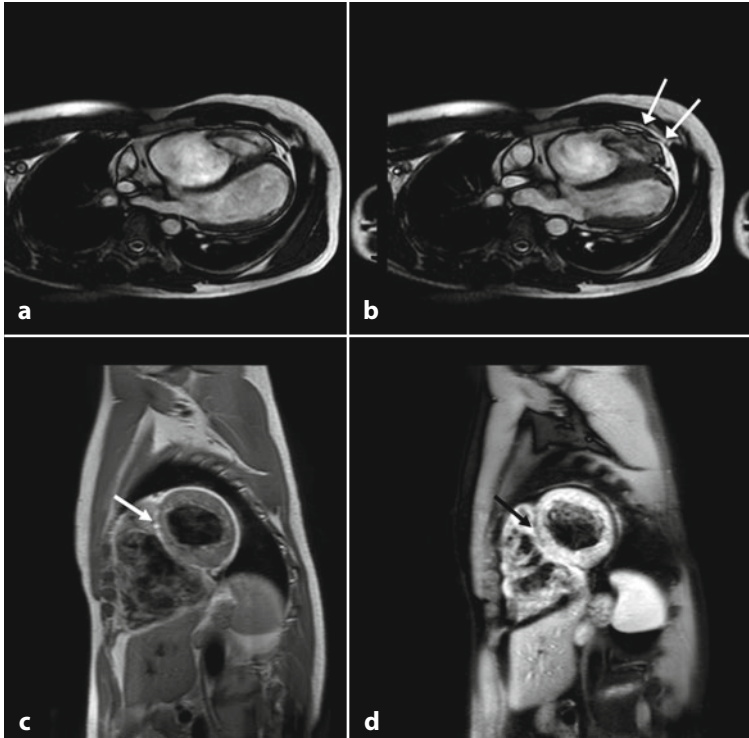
Magnetic resonance images of arrhythmogenic right ventricular cardiomyopathy in a 40-year-old patient. End-diastolic (a) and systolic (b) still-frames obtained from four-chamber stack steady-state free precession cine-imaging, showing systolic bulging of multiple small aneurysms (*arrows*) of the right ventricle (RV) free wall in the apex and subtricuspid area. The volume calculations showed RV dilatation and severe systolic dysfunction. T1 without (c) and with (d) fat saturation showing fatty infiltration of the anterior interventricular septum (*arrow*). The fatty infiltration appears to be hyperintense in T1, and dark in the fat saturation images
